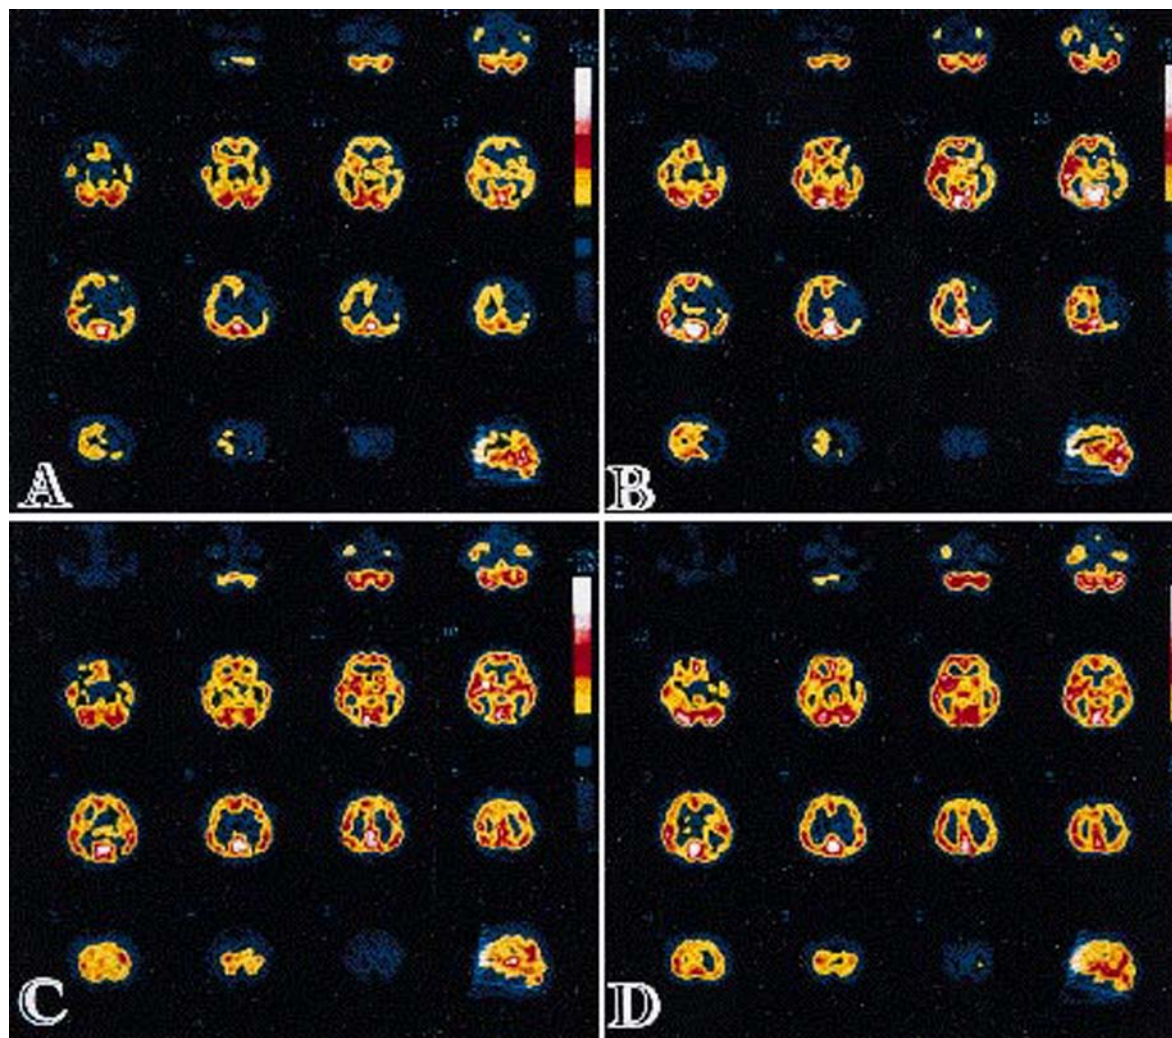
Case 8. Pre- and postoperative single-photon emission computerized tomography with *N*-isopropyl- $[^{123}\text{I}]$ iodoamphetamine (IMP-SPECT) findings. Upper: Preoperative IMP-SPECT images without (A) and with (B) an acetazolamide injection showing low uptake area in the left frontal and parietal lobes. Lower: Postoperative IMP-SPECT images without (C) and with (D) an acetazolamide injection showing remarkable improvement in the left hemisphere.
